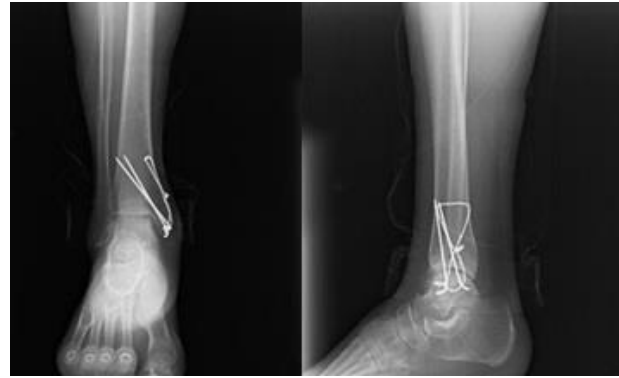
Postoperative 12th month ankle anterior-posterior and lateral radiography
